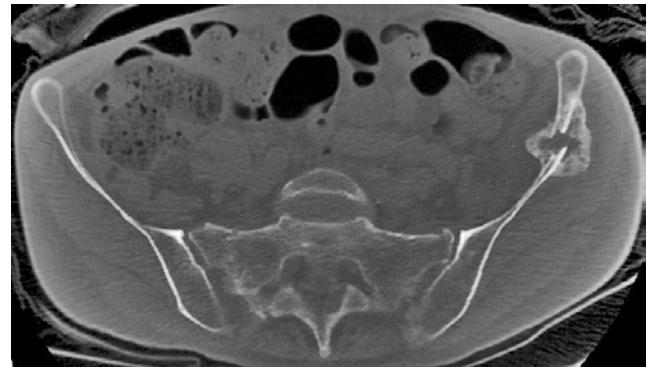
Axial CT scan demonstrating bilateral nondisplaced sacral fractures.
